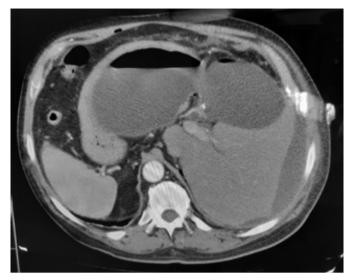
Abdominal CT showed a 9.5x9 cm right sub-hepatic fluid collection compressing the stomach.
